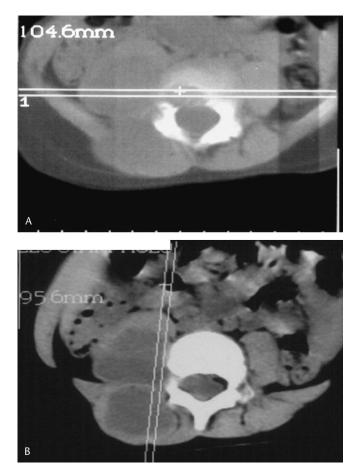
CT scan of primary site at diagnosis.
